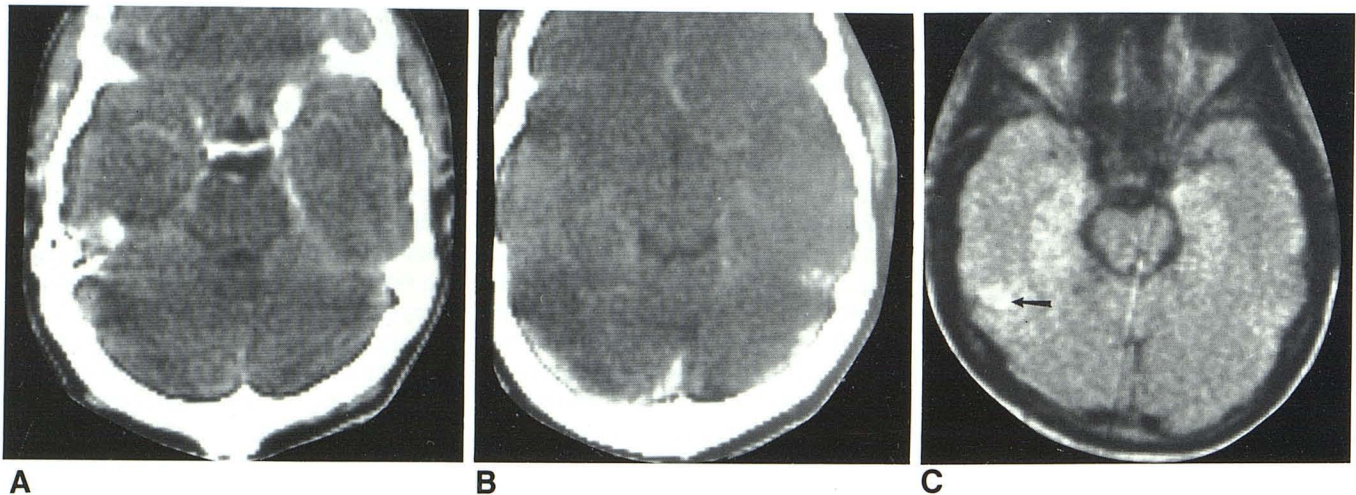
Case 2. A, Contiguous 8-mm-thick normal postinfusion CT scans. B, SE 1080/80 image. Abnormal high signal in right posterior middle temporal gyrus (arrow).
